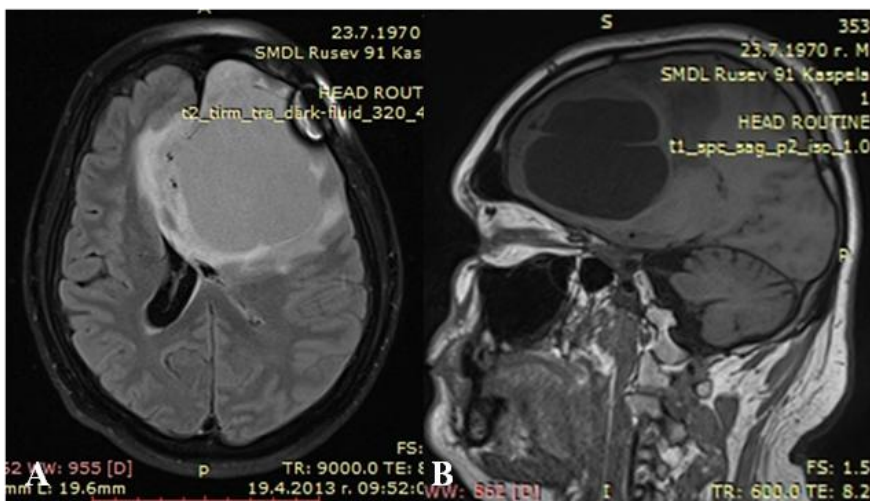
MRI of astrocytoma grade II:
